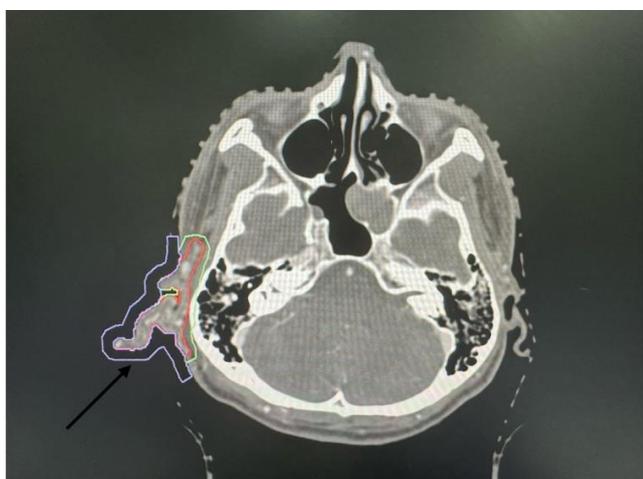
Planning CT scan with contrast. It shows red, gross tumor volume and green, planning target volume pointed with arrow.
